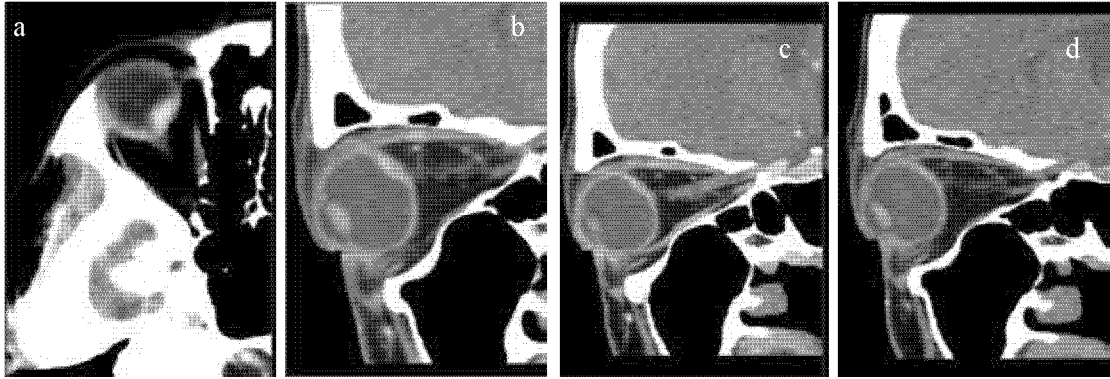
Initial pre-treatment and series follow-up CT images of 49 year-old female choroidal melanoma patient a) pre-treatment CT image, tumor 4.0 \* 11.2mm; b) 1.5-year follow-up CT image, tumor 3.7 \* 9.5mm; c) 2.5-year follow-up CT image, tumor 3.4 \* 9.5mm; d) 3.5-year follow-up image, complete response.
